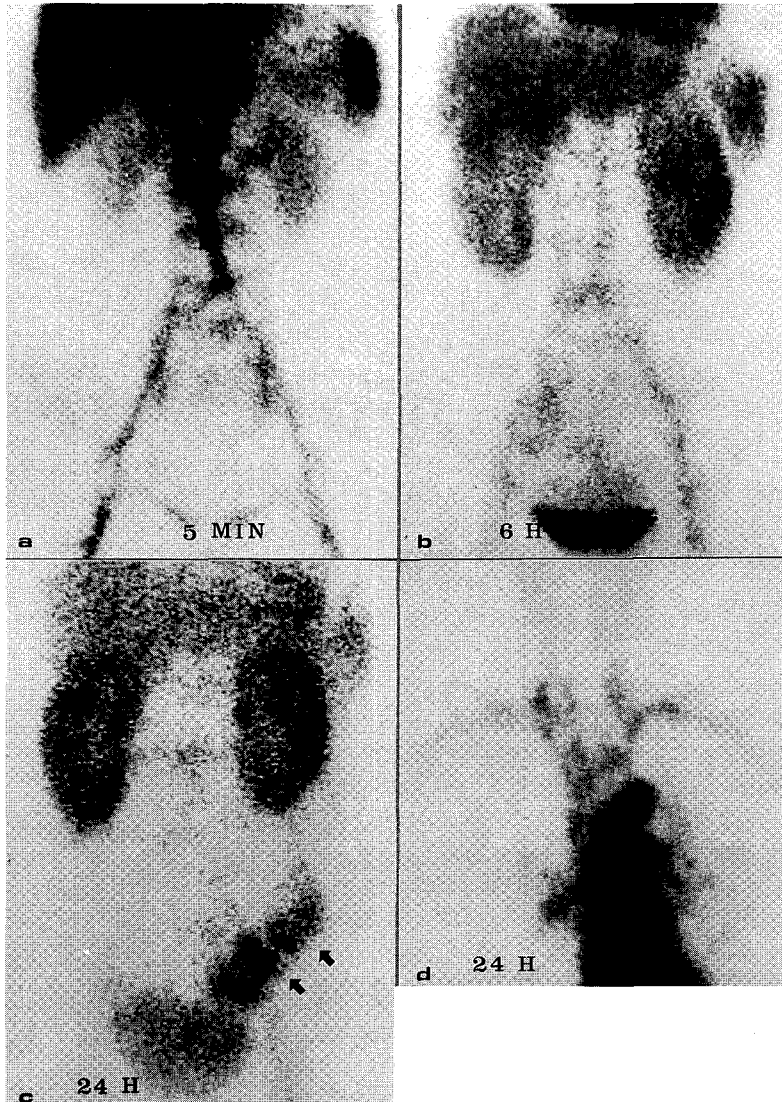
(a-d). Positive scintigraphy. There is no definite intestinal activity until 6 hours (a-b), but colon activity (arrows) is shown on 24 hour-delayed scan (c). Thyroid uptake is not noted at 24 hours (d).
